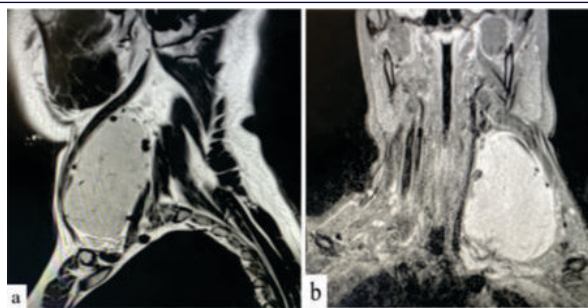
Magnetic resonance imaging showing a large well defined oval lesion displaying markedly hyperintense signal intensity on T2W TIRM sequences.
